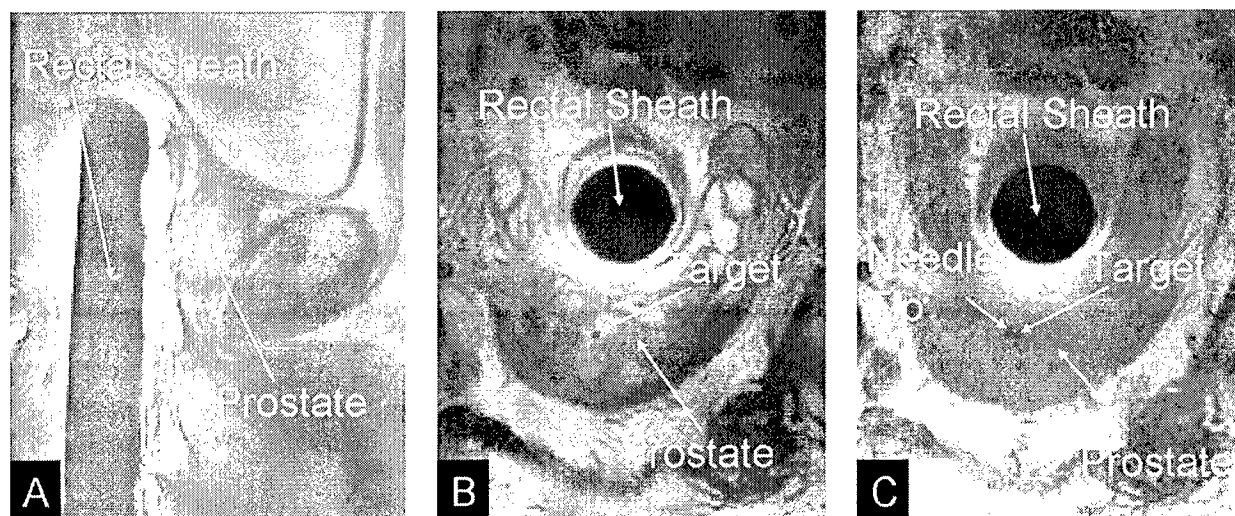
MR images of the prostate. Panel A: Sagittal T2 weighted MR image containing rectal sheath and prostate. Panel B: Axial T2 weighted MR image containing prostate and rectal sheath with selected target. Panel C: Axial T1 weighted image after insertion of the needle, verifying accurate targeting, thus small displacement between target point and the void created by the needle tip.
